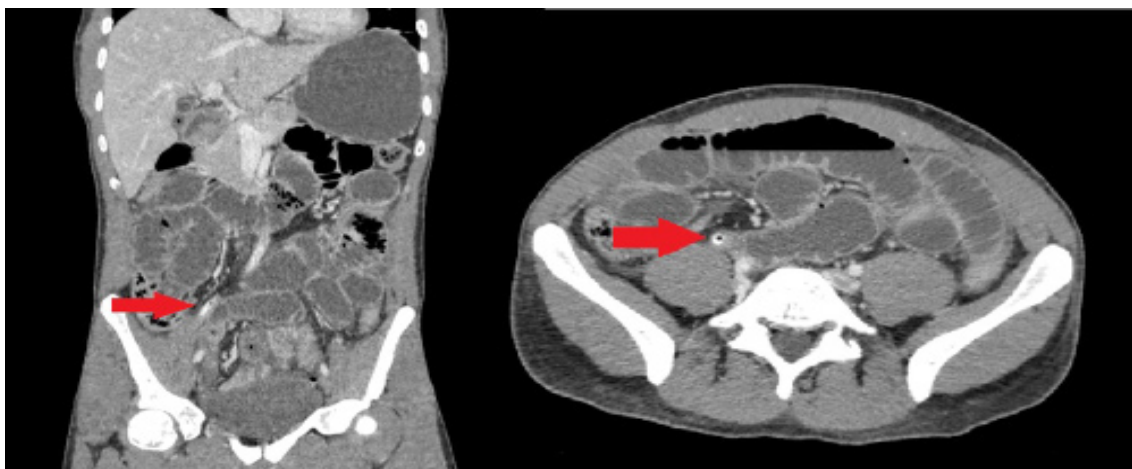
CT scan. Arrow: Meckel's Diverticulum
